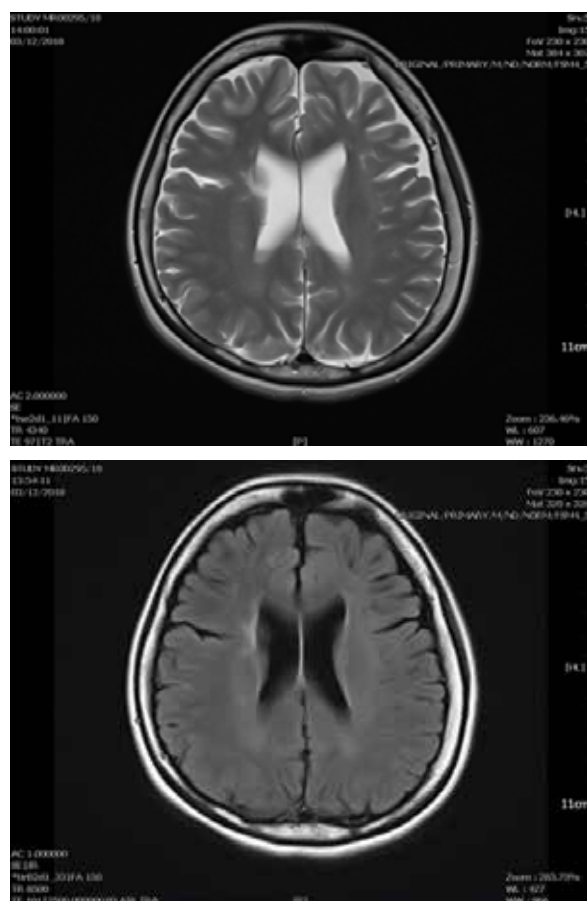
Brain MRI T2-weighted (above) and FLAIR (below) scans.
